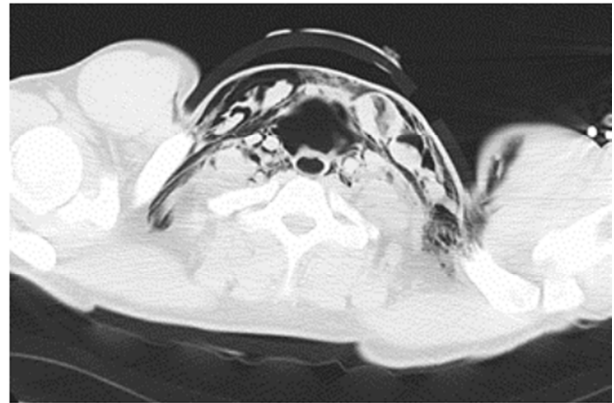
Preoperative CT of the neck showed gas accumulation in the neck, discontinuous tracheal flow, and irregular lumen.
